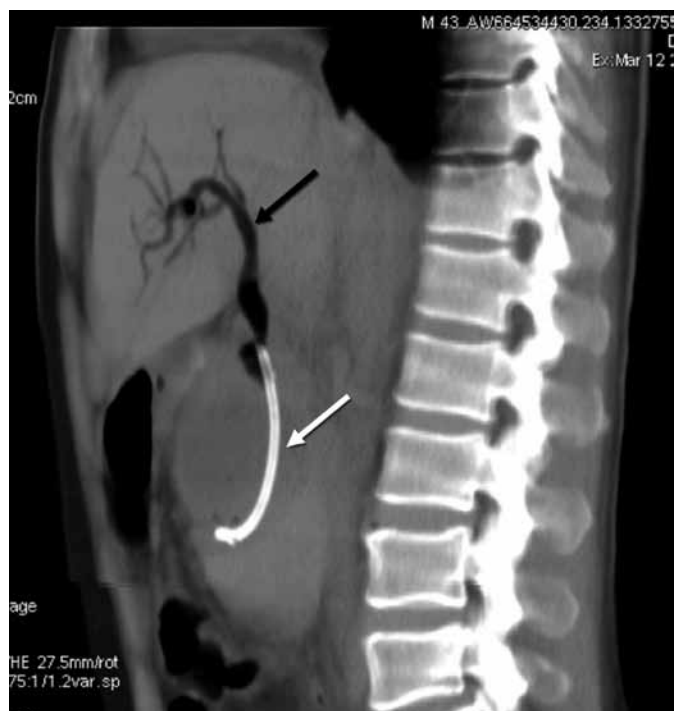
Sagittal CT image of the abdomen demonstrating biliary tree filled with air (black arrow) and stent in situ in common bile duct (white arrow).
